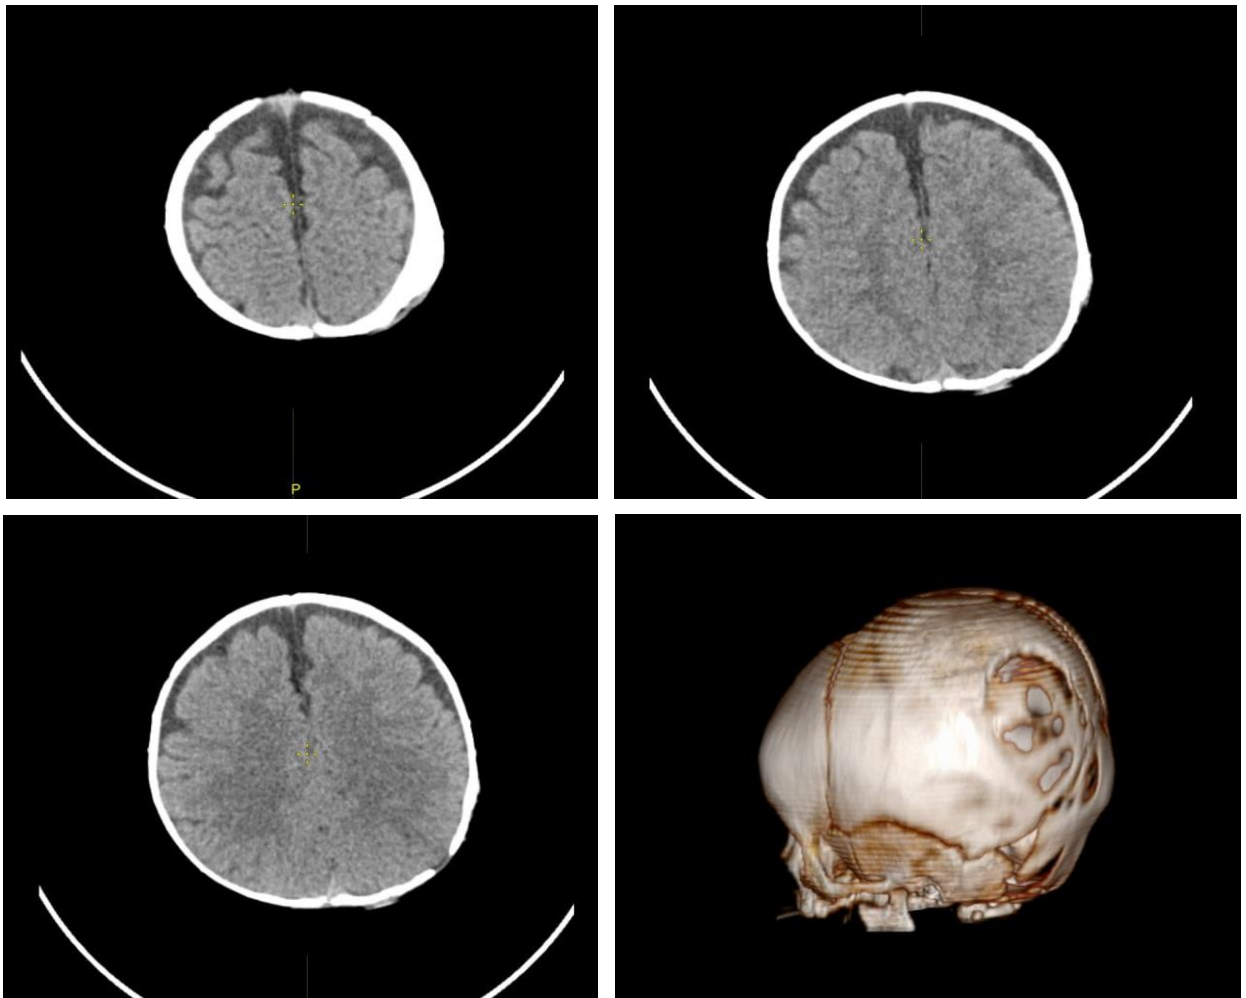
Vemor E.F. control multispiral computed tomography of the brain 1 month after the operation.
